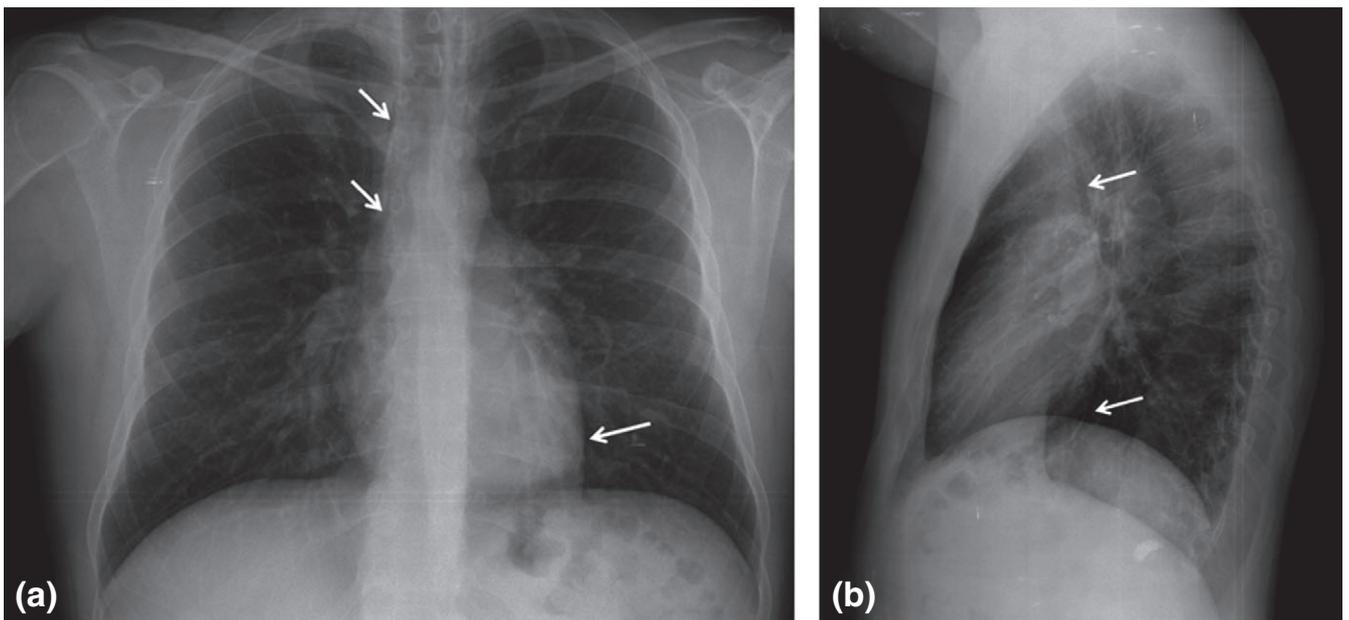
(a) Anteroposterior and (b) lateral chest X-rays showing slight mediastinal emphysema (arrows).
